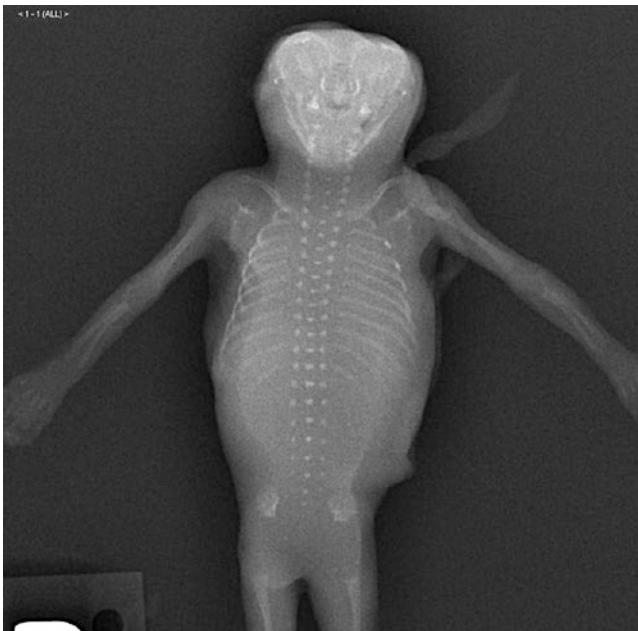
Anencephaly. This AP fetal radiograph shows absence of the skull vault and brain tissue. The skull base and facial bones are present
